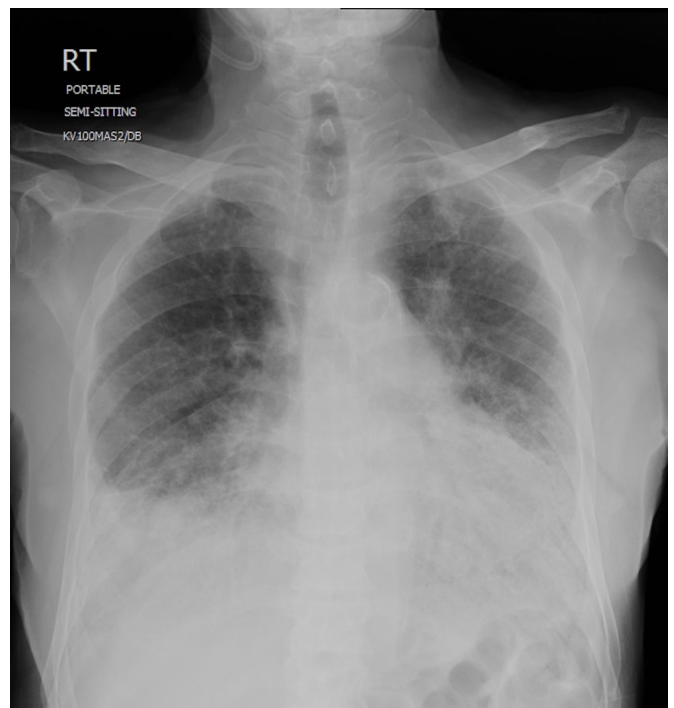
Chest X-ray after treatment showed improvement of bilateral pulmonary infiltrates.
